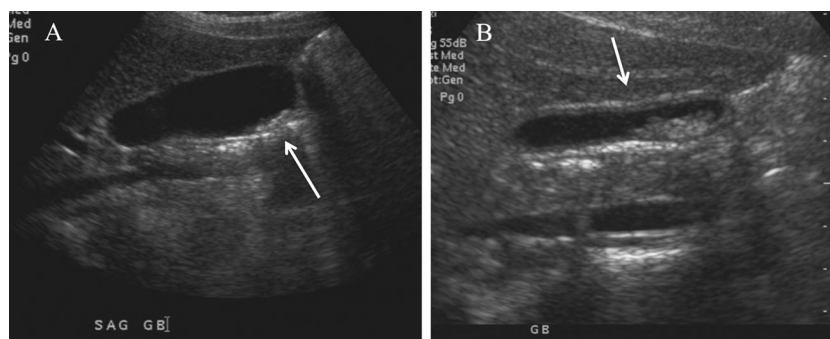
Seventeen-year-old girl with HbSS and multiple visits for right upper quadrant pain. The first US showed cholelithiasis (*arrow*), as did an abdominal CT performed 5 days later (not shown) (a). An ultrasound
